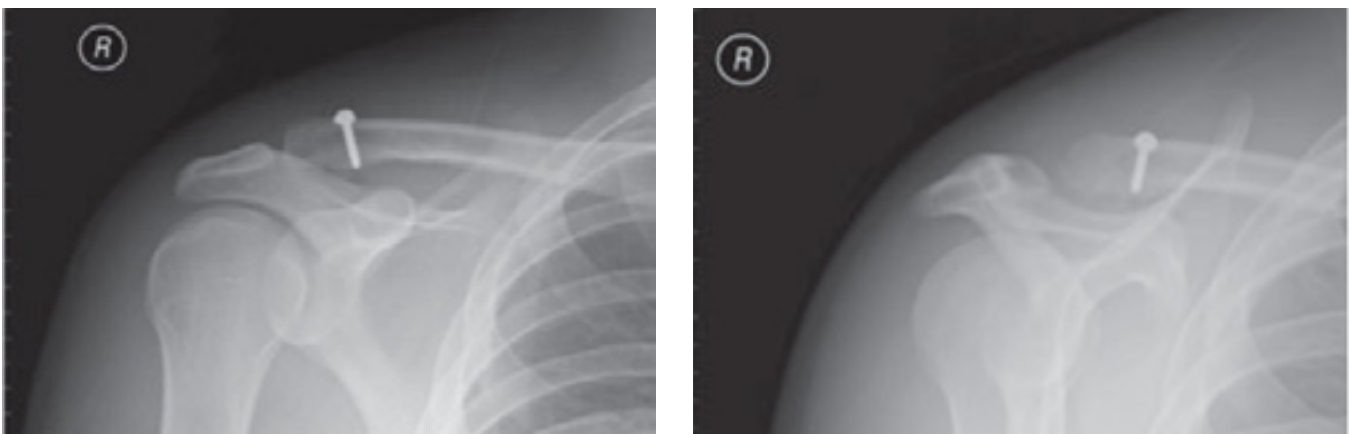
(A) Postoperative anteroposterior view radiograph showing a reduced and Surgilig stabilized acromioclavicular joint (ACJ) dislocation (B) Postoperative lateral scapular view radiograph showing a reduced and Surgilig stabilized ACJ dislocation.
